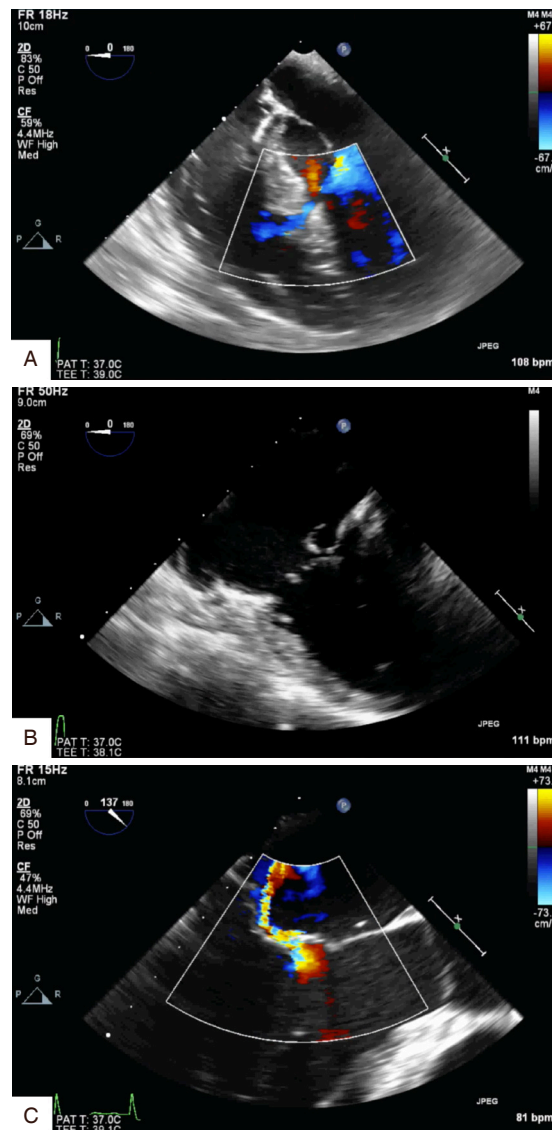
A: Intraoperative transoesophageal echocardiography (TOE) 4 chambers view with Doppler colour demonstrating the flow through the ventricular septal defect; B: intraoperative TOE, 4 chambers view, demonstrating the complete detachment of the tricuspid septal leaflet due to transection of the head of the papillary muscle; C: intraoperative TOE, apical long axis view with Doppler colour demonstrating the eccentric jet of mitral regurgitation caused by prolapse of A2 segment secondary to complete transection of the primary chordae
